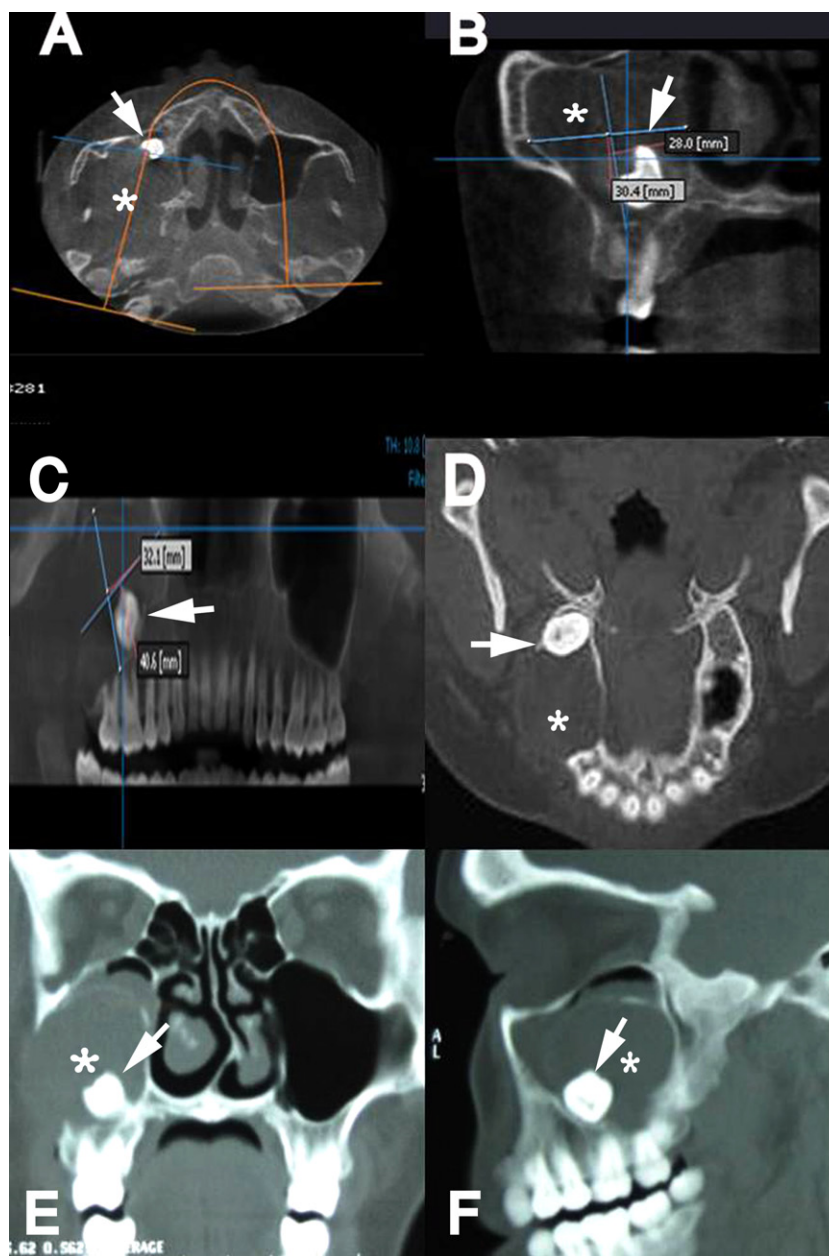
Odontogenic keratocyst. *CBCT*: A–C (axial, coronal, and panoramic reformatted images, respectively). *MDCT*: D–F (axial, coronal MIP and sagittal oblique MIP images, respectively) show cystic expansile lesion involving the right maxilla (asterisk). It showed well-defined, thin corticated borders and vertically impacted unerupted upper first molar (arrows). Both modalities were identical in the detection of lesion location, internal structure, and cortical thickening.
